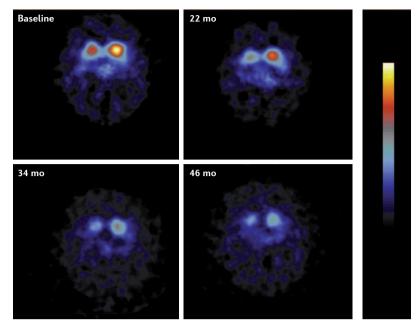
A single-photon emission computerized tomographic (SPECT) scan of dopamine transporter density in a Parkinson's disease patient shortly after diagnosis and serially for 46 months. There is asymmetric loss particularly in the posterior putamen, which progresses bilaterally over time. Levels of SPECT activity are colour-coded from low (black) to high (yellow/white).  $\beta$ -CIT, 2 $\beta$ -carboxymethoxy-3 $\beta$ (4-iodophenyl)tropane. Adapted, with permission, from REF. 95 © (2002) American Medical Association.
